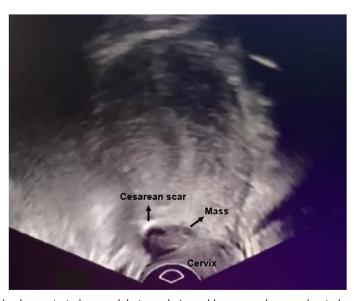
Transvaginal sonography demonstrated a round, heteroechoic, and hypervascular mass located on the cesarean section scar defect (isthmus).
